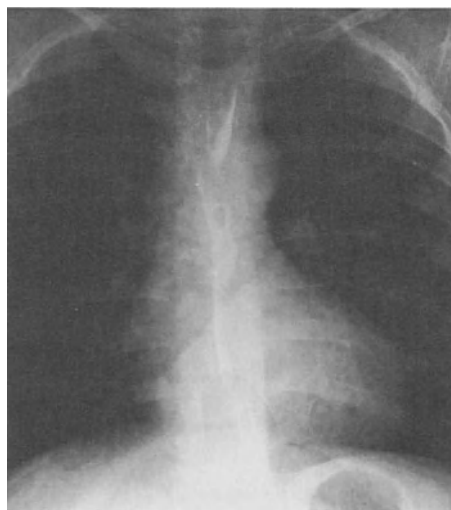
Chest X-ray in Tetralogy of Fallot showing the typical boot-shaped appearance of the heart and pulmonary oligemia.
